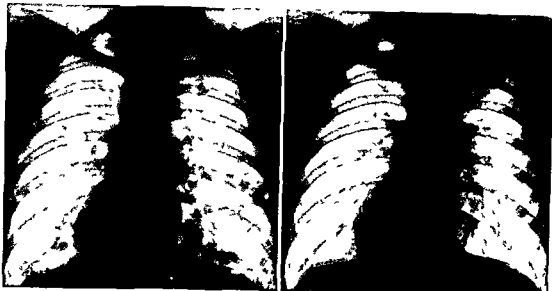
Roentgenograms of chest showing extensive pulmonary metastases from embryonal carcinoma of testis before October 1, 1934 and November 23, 1938 after x ray
